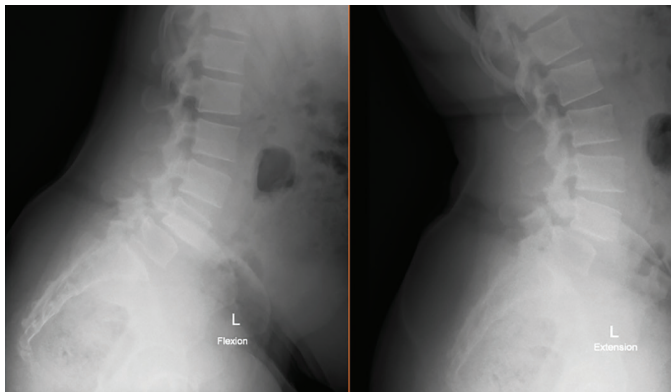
Flexion-extension dynamic X-rays
